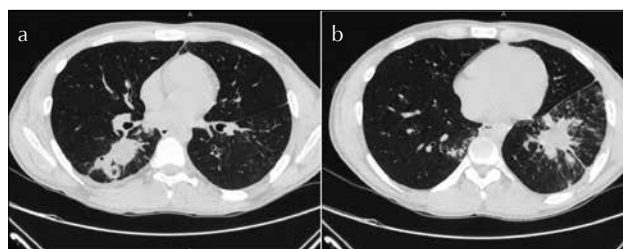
a, b. Chest CT showing consolidations in RLL and LL
